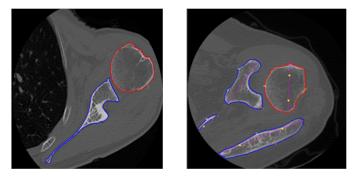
Results of two CT scan images after the recognitionbased segmentation. Scapula parts (in blue) are segmented and recognized, the humeral head (in red) is also segmented and detected.
